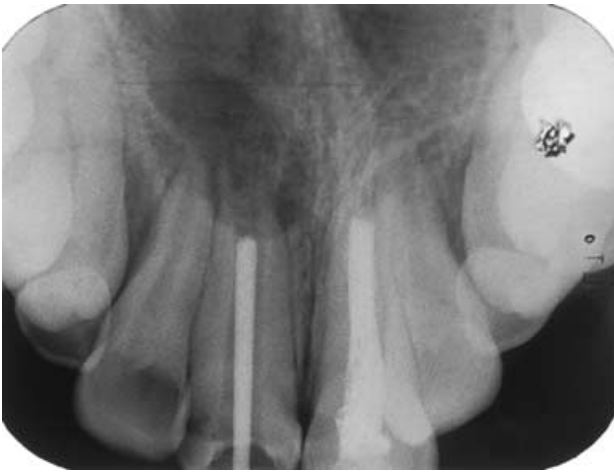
Periapical radiograph showing the master point leaving 2 mm in the apical part of the root for the obturation with MTA.
